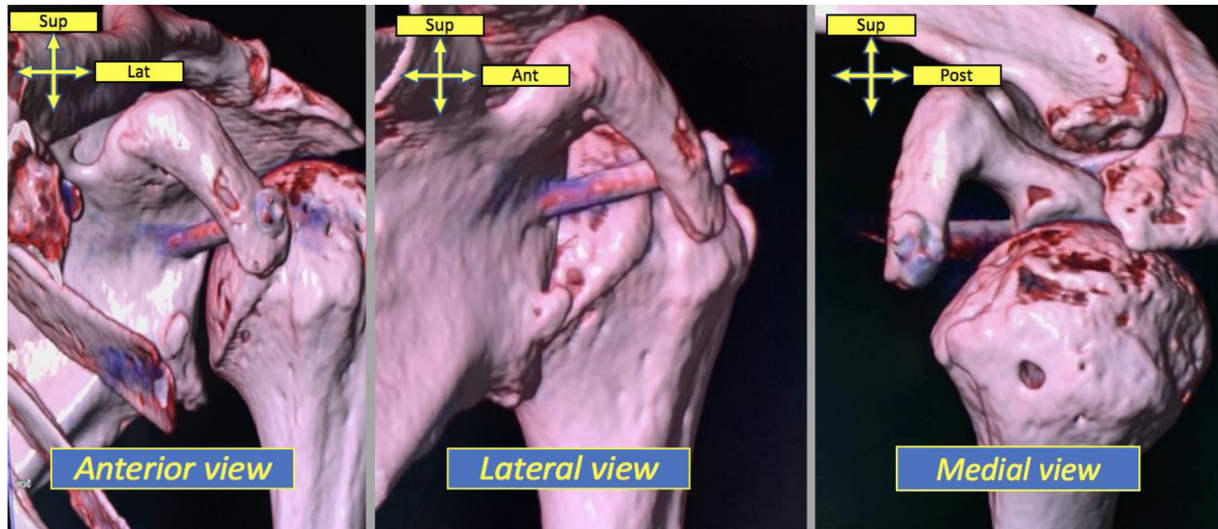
Three-dimensional reconstructions on controlled computed tomography at 6 months postoperatively showing a good healing of the coracoid process after an open Trillat procedure. The coracoid process has to be mobilized medially and downward. Yellow arrows show the orientation of the images. (Ant, anterior; Lat, lateral; Post, posterior; Sup, superior.)
